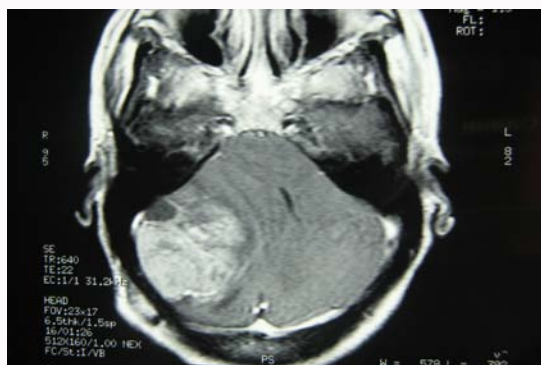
Radiological appearance of the lesion, Axial T1W MRI with gadolinium showing a large posterior fossa lesion involving the right cerebellar hemisphere, with local mass effect on the fourth ventricle, the lesion is heterogeneous.
